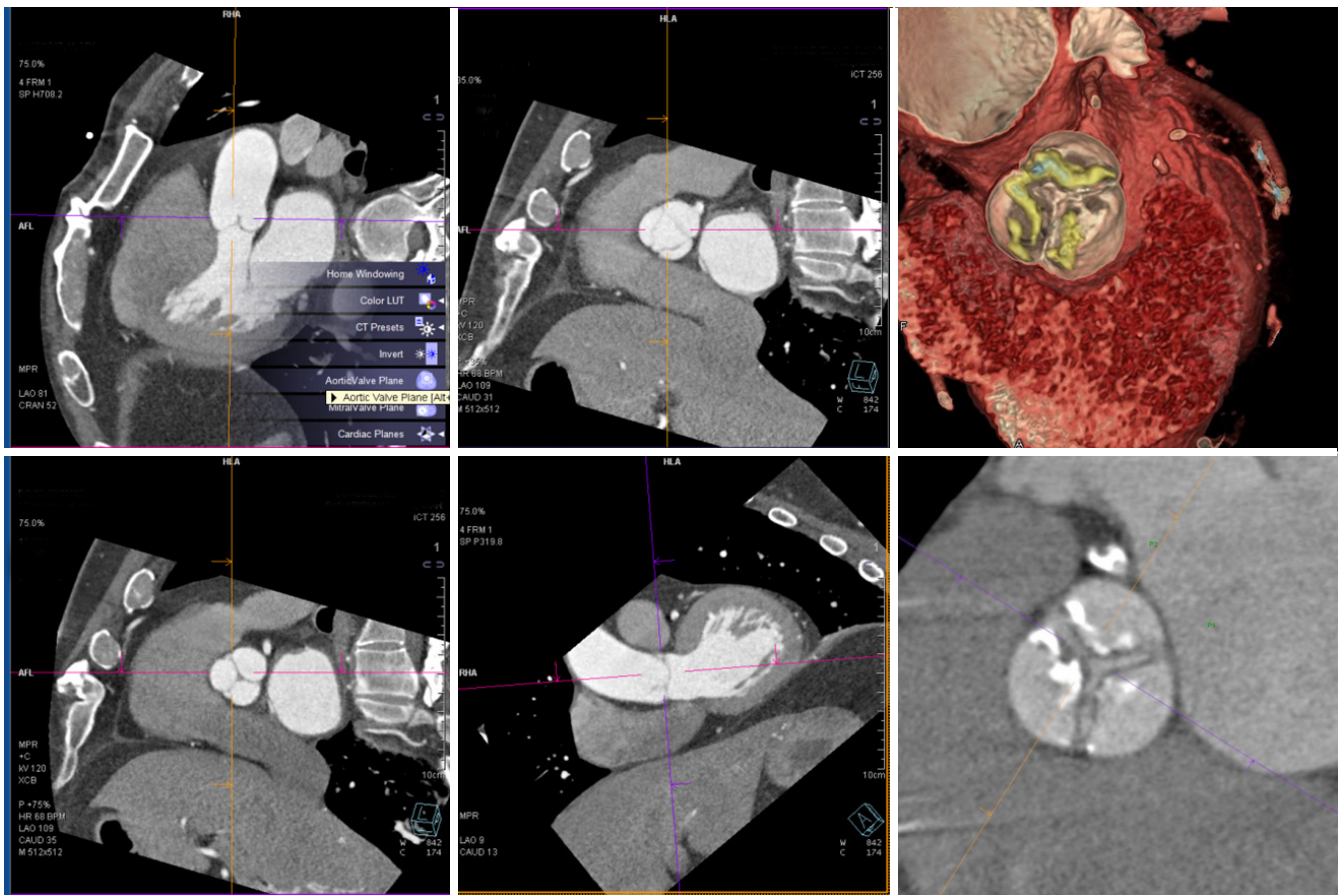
This figure shows CT images of a normal aortic valve (left panels) with regular systolic opening and diastolic closing. The right panels show a calcified valve with restricted opening in a patient with severe aortic stenosis. CT, computed tomography.
